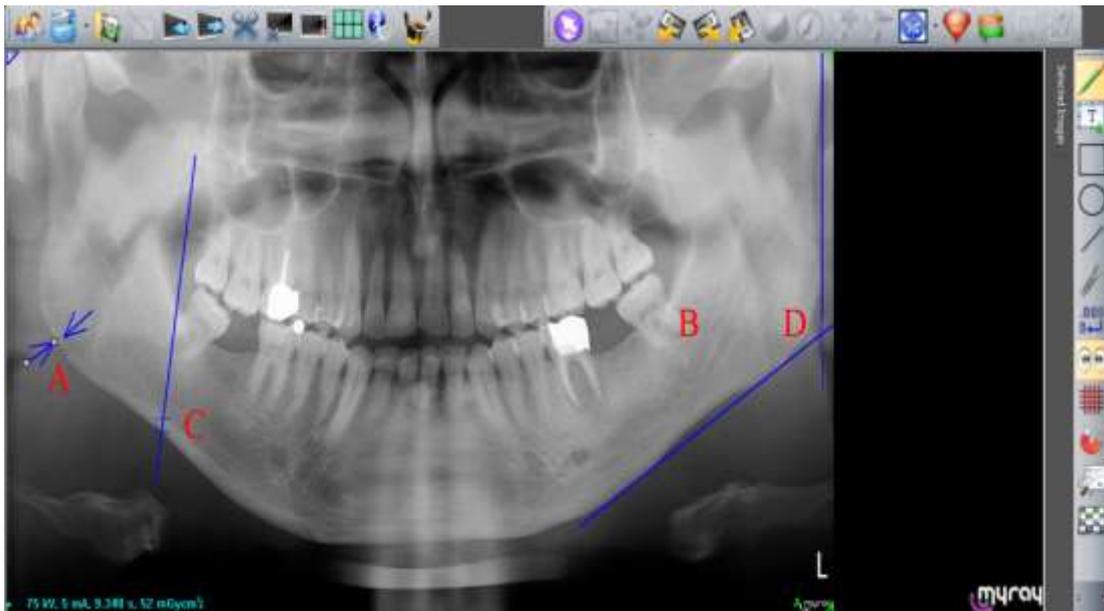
A - Gonial cortical bone thickness. The median projection on angulusmandibula bisector of the angle from the parts formed; B - mandibular canal wall resorption on the orthopantomography; C - antegonial index. The cortical width in the region anterior to the gonion at a point identified by extending a line of “best fit” on the anterior border of the ascending ramus, down to the lower border of the mandible; D - gonial angle measurement. The measurement site in the radiograph was determined to be a point on the mandibular border at the intersection of a line tangential to the most inferior points at themandibular angle and the lower border of the mandibular body, anda line tangential to the posterior borders of the ramus and the condyle.
